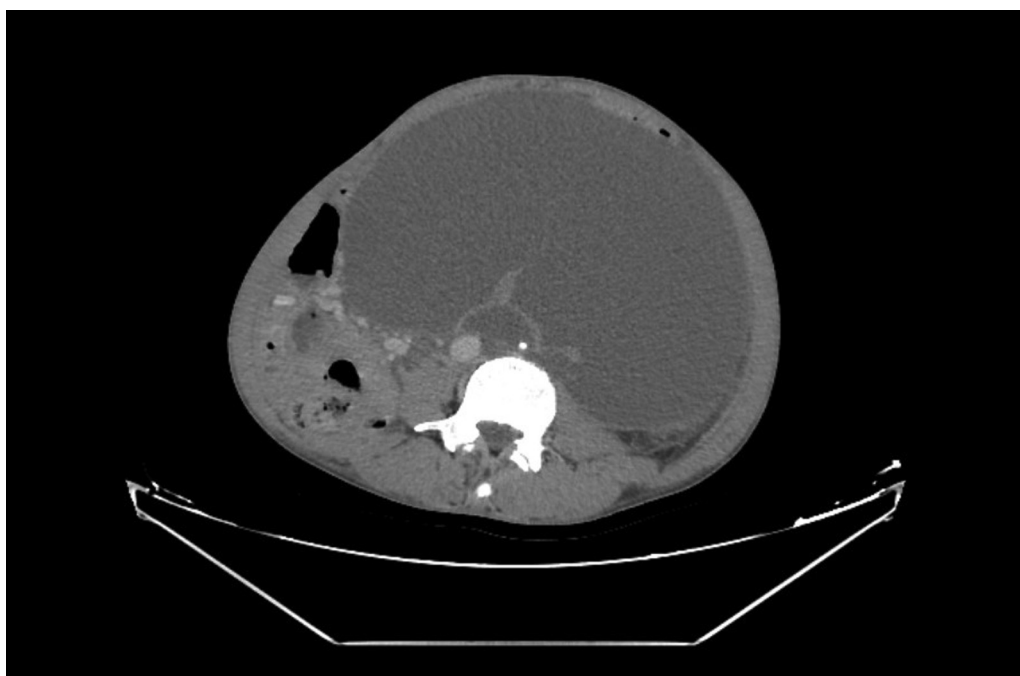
Cross-sectional contrast-enhanced computed tomography below the level of right kidney is showing a cystic mass acquiring more than two third of peritoneal cavity displacing contents to right side.
